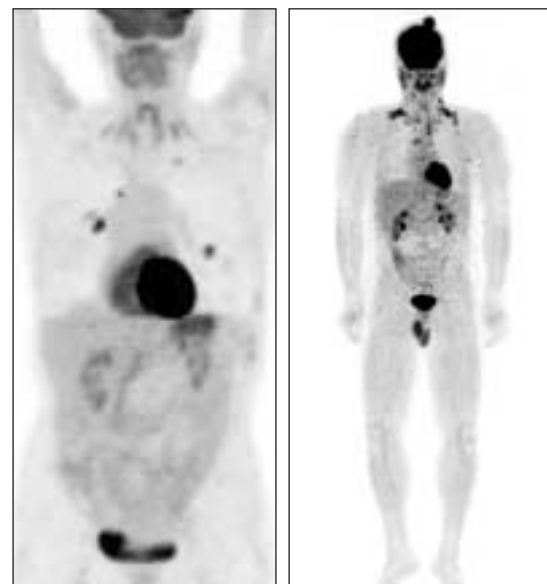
Whole-body F-18 FDG-PET. A: Limited whole-body image from chin to upper thigh. B: True whole-body image from top of skull to toes. Of note, patient on the right has a scalp lesion biopsy, which revealed melanoma.
